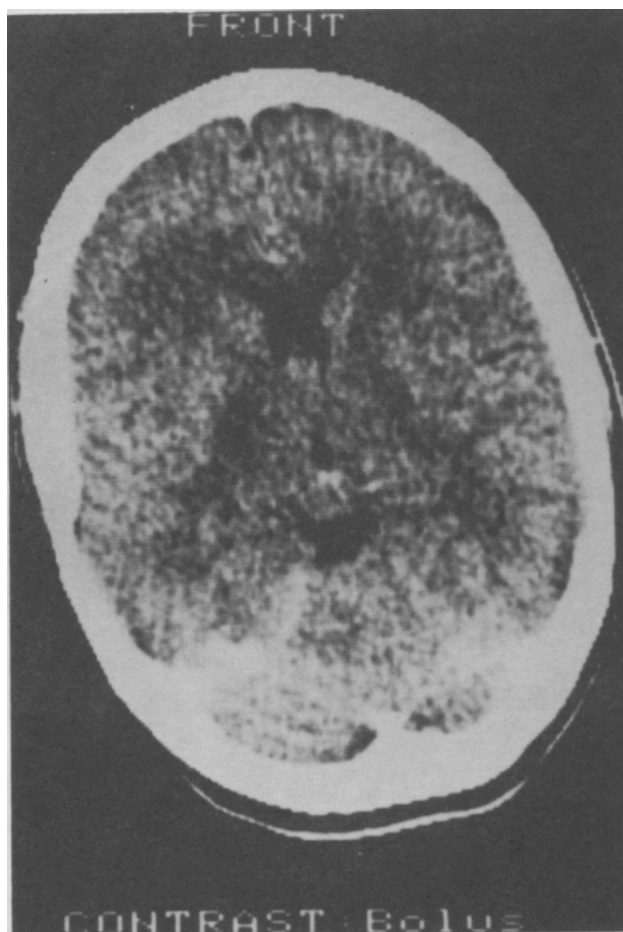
CT head scan, with contrast medium, of Case 2. The area of low attenuation in figure 1 is not enhanced, suggesting a small right limbic infarct consistent with the clinical findings.
